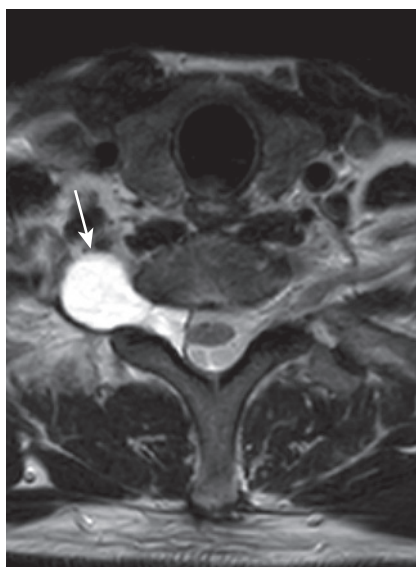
Brachial Plexus Injury. Axial T2-weighted magnetic resonance imaging of the cervical spine shows a pseudomeningocele (*arrow*) resulting from nerve root avulsion.
